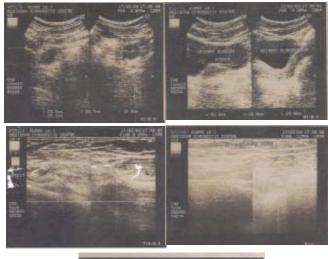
Ultrasonography of Pelvis Showing Presence of Uterus & Bilateral Tubes, Ovaries & of Inguinal Canal Showing Absence of Testes Both Sides
